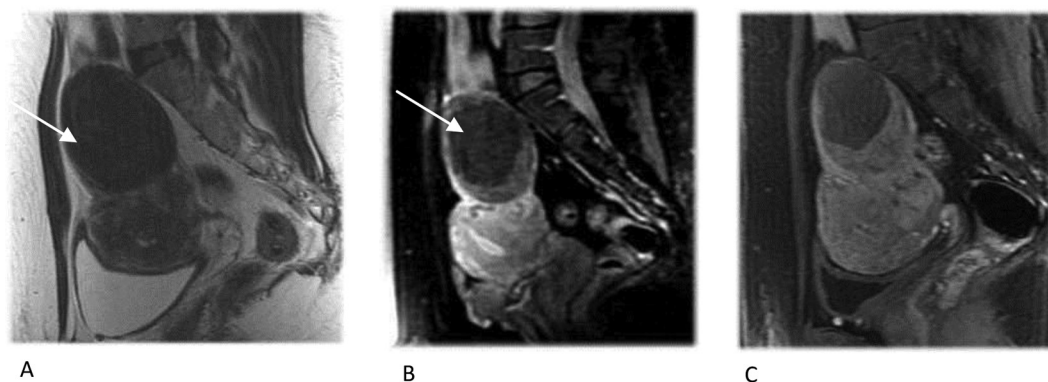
(A) Pretreatment T2-weighted sagittal image of a 44-year-old woman demonstrating one uterine fibroid (arrow) measuring about 97 mL (volume). Her SSS and UFS-QOL is 40.6 and 64, respectively. (B) Posttreatment enhanced T1-weighted image of the patient demonstrating the resulting NPV ratio (53.6%). The low signal intensity area (arrow) is indicative of the posttreatment necrotic area. (C) The 6-month follow-up enhanced T1-weighted image demonstrating the volume of fibroid decreased to 61.2 mL. The volume decrease rate is 36.9%. The SSS and QOL is 9.3 and 89.7, respectively. The improvement of SSS and UFS-QOL is 31.3 and 25.7, respectively. NPV = nonperfused volume; SSS = Symptom Severity Score; UFS-QOL = Uterine Fibroid Symptoms and Quality of Life Questionnaire.
